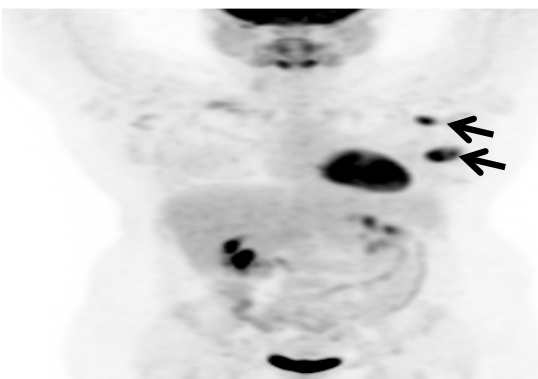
(A) Coronal PET MIP image shows a hypermetabolic mass in the upper outer quadrant of the left breast with SUV 9.2 (solid arrow), and several enlarged FDG avid left axillary lymph nodes (dotted arrow).
